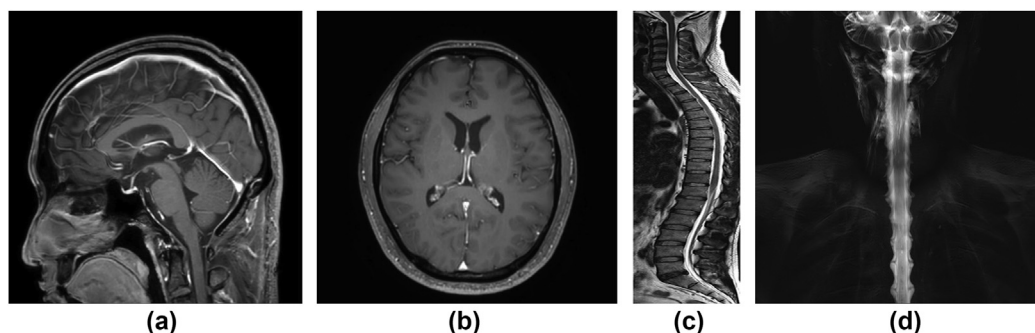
Representative case of a 39-year-old man with posterior neck pain. (a) Sagittal enhanced T1-weighted brain MRI image showing no definite venous engorgement, enlarged pituitary gland, or brain sagging. (b) Axial enhanced T1-weighted image showing no diffuse pachymeningeal enhancement. (c) Sagittal spine MRI image showing epidural fluid collection within the ventral aspect of the spinal canal at cervicothoracic junction and the dorsal aspect of the spinal canal at thoracolumbar junction. (d) Maximum intensity projection 2D MR myelography images showing extensive CSF leakage at the craniocervical junction, and upper C-spine levels.
